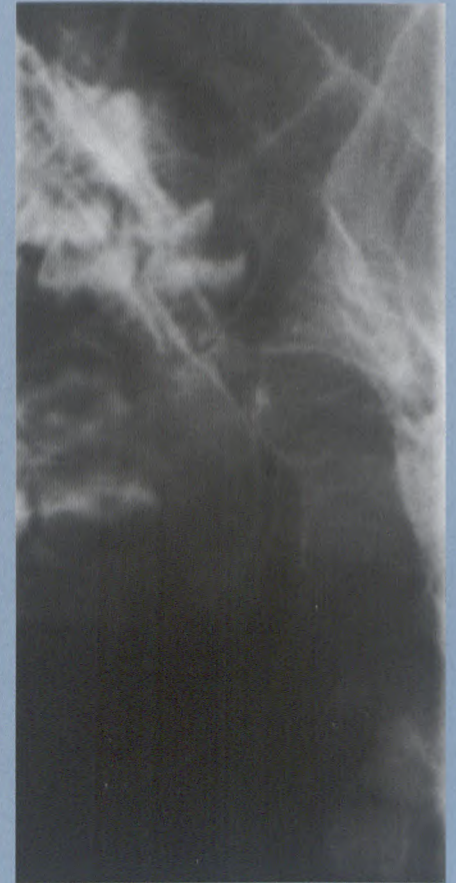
Soft tissue lateral neck radiograph after instillation of dilute barium to outline airway.
